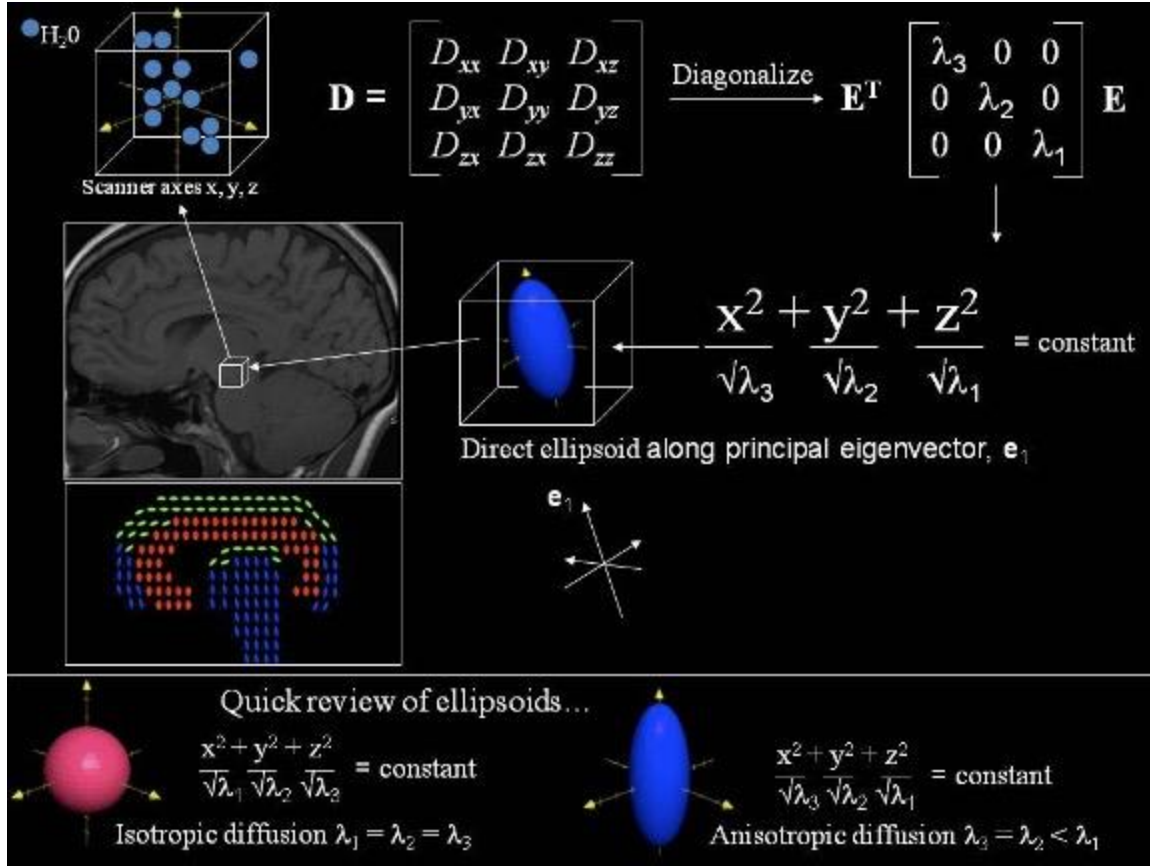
Calculating the tensor. Reprinted with permission from Gallagher, T. A., Alexander, A. L., & Field, A. S. (2012). Diffusion Tensor Magnetic Resonance Imaging: Physical Principles. In S. H. Faro, F. B. Mohamed, M. Law, & J. T. Ulmer (Eds.), Functional Neuroradiology: Principles and Clinical Applications (pp. 709-729). Springer US. [https://doi.org/10.1007/978-1-4419-0345-7\\_35](https://doi.org/10.1007/978-1-4419-0345-7_35)
